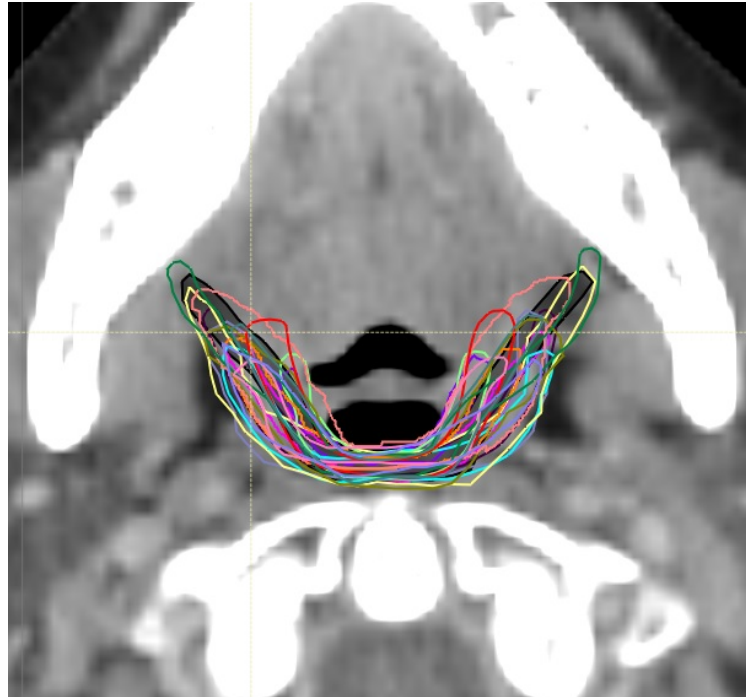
Example of PI-SMPCM contours on a single axial CT slice. The gold standard contour is shown in black
